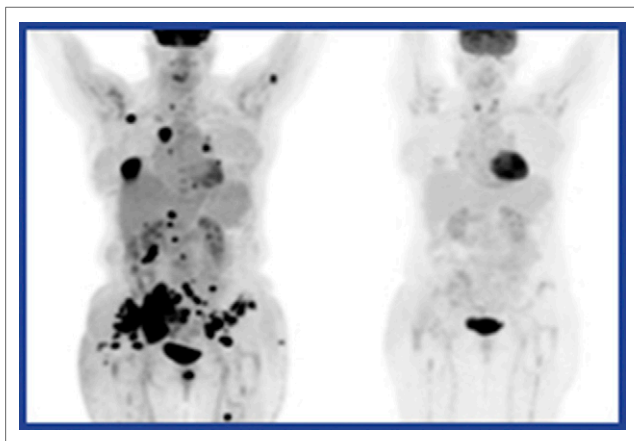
Example ^{18}F -FDG PET images of patient with non-small cell lung cancer treated with the PD-L1 inhibitor atezolizumab at baseline (left) and at week 6 after initiation of treatment (right). Patients in the study with metabolic response by European Organisation for Research and Treatment of Cancer criteria at week 6 had higher overall response rates by RECIST 1.1 than metabolic nonresponders (74% and 7%, respectively).
